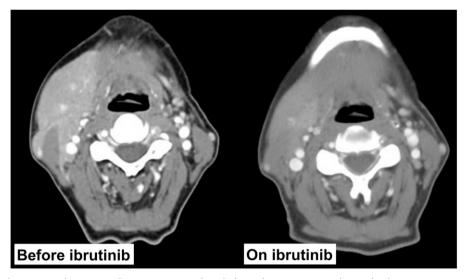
Computed tomography scans showing a partial radiological response to ibrutinib therapy in a patient with MYD88mutated IgG lymphoplasmacytic lymphoma.
